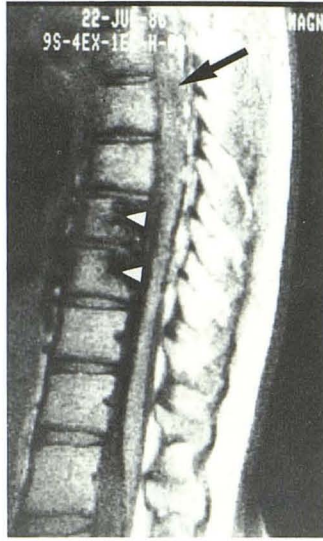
Cobb syndrome with thoracic (T7) intramedullary arteriovenous malformation (arrow) in 18-year-old boy. Sagittal T1-weighted (400/28) image shows that vertebral angioma involves T8 and T9 with huge low-intensity signal within vertebral body (arrowheads).
